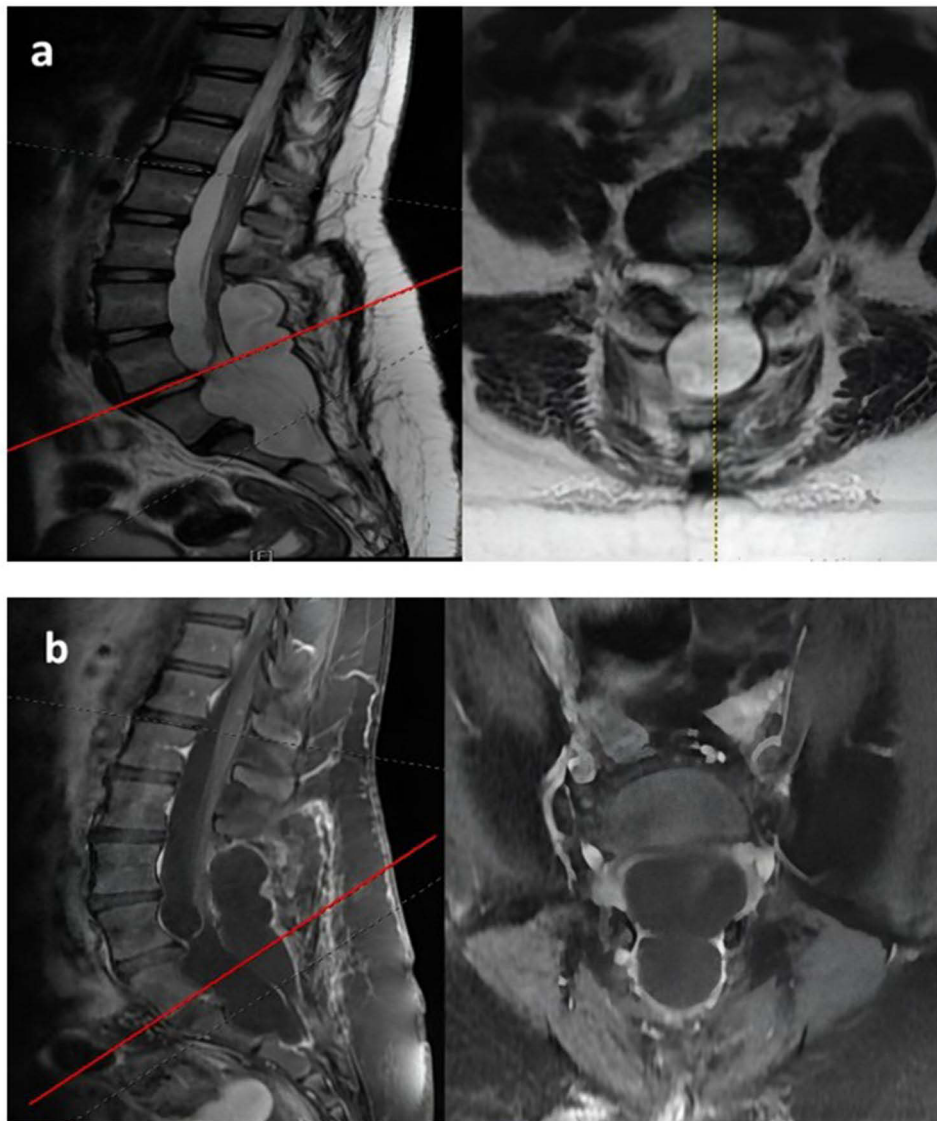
Preoperative non-contrast lumbar MRI showing an intradural space-occupying lesion that is hypointense on T1W (a) and hyperintense on T2W (b) in association with expansion of the spinal canal.
